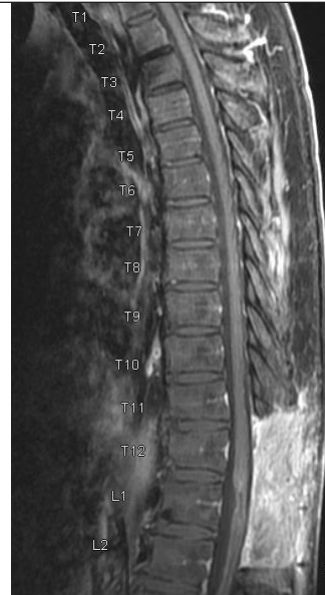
Postoperative T1-sagittal magnetic resonance imaging (MRI) of the patient shows a small enhancement and no recurrence of cyst with well decompressed conus medullaris.
